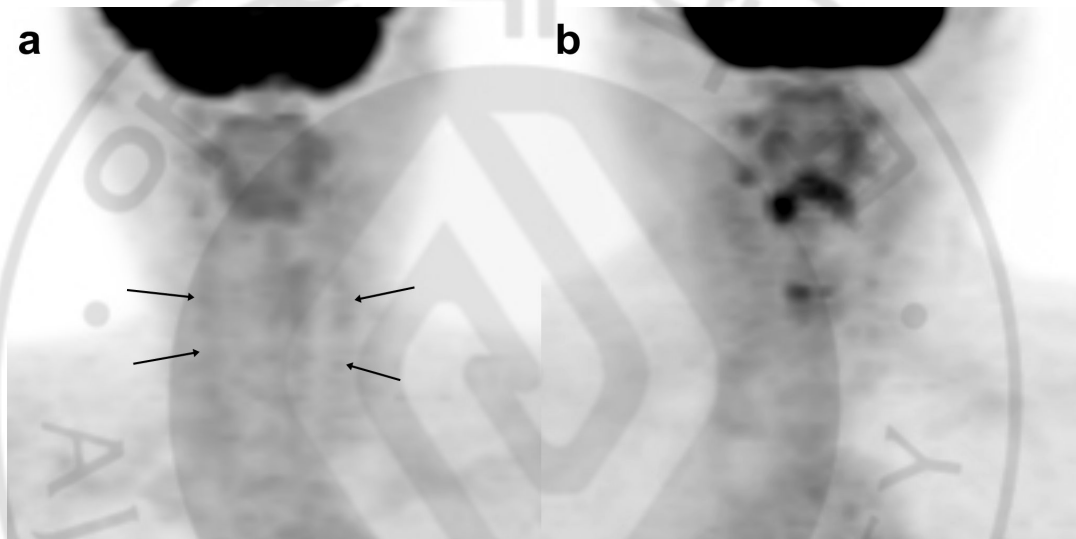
Representative maximum intensity of projection images of ^{18}F -FDG PET/CT. (a) A 66-year-old man without metabolic syndrome shows mildly increased FDG uptake along bilateral common carotid arteries (arrows). (b) A 63-year-old man with metabolic syndrome has no remarkable FDG uptake in bilateral carotid arteries. Framingham risk score of the subject with high uptake but no metabolic syndrome was comparable with that of subject with low uptake with metabolic syndrome (11.6 vs. 13.4).
